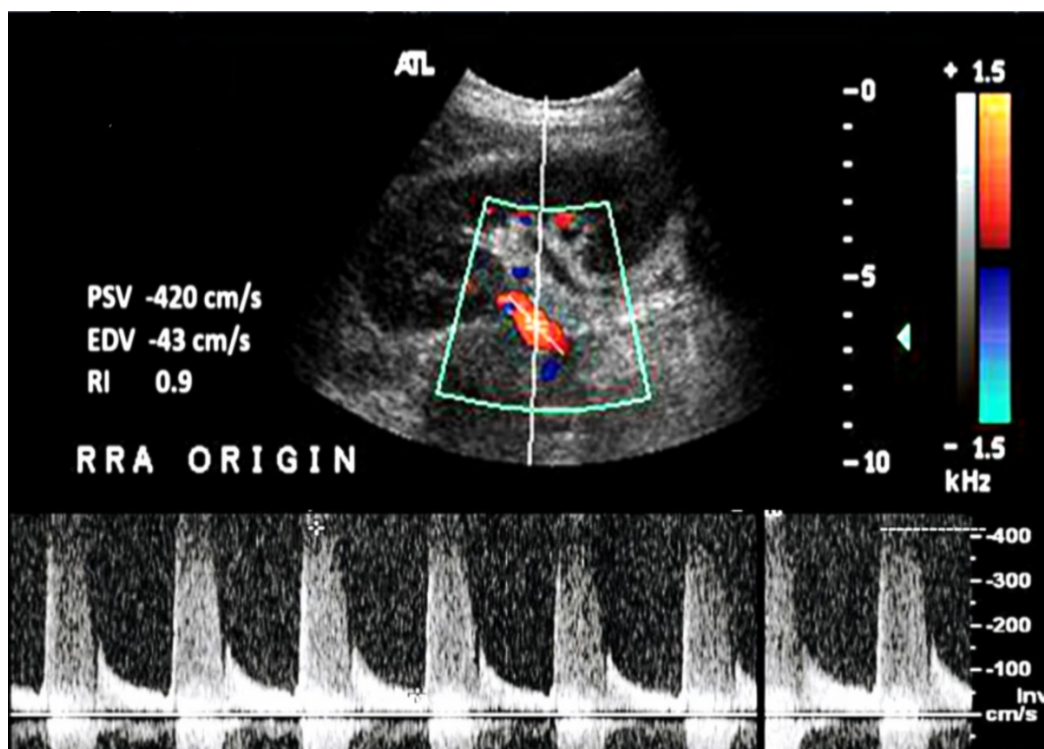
Doppler ultrasound image showing aliasing at right main renal artery origin (PSV 420 cm/s) in a 27-year-old male
